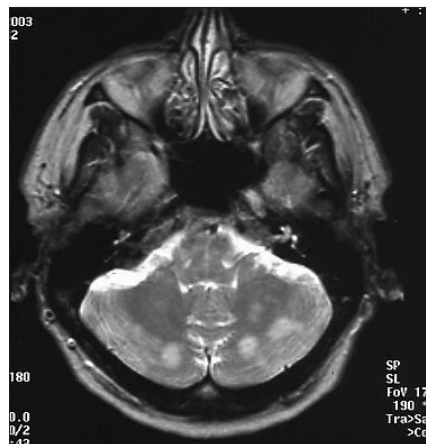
Sagittal fluid attenuated inversion recovery (FLAIR) image of brain showing multiple areas of hyperintensity in the parieto-occipital region and cerebellum.
